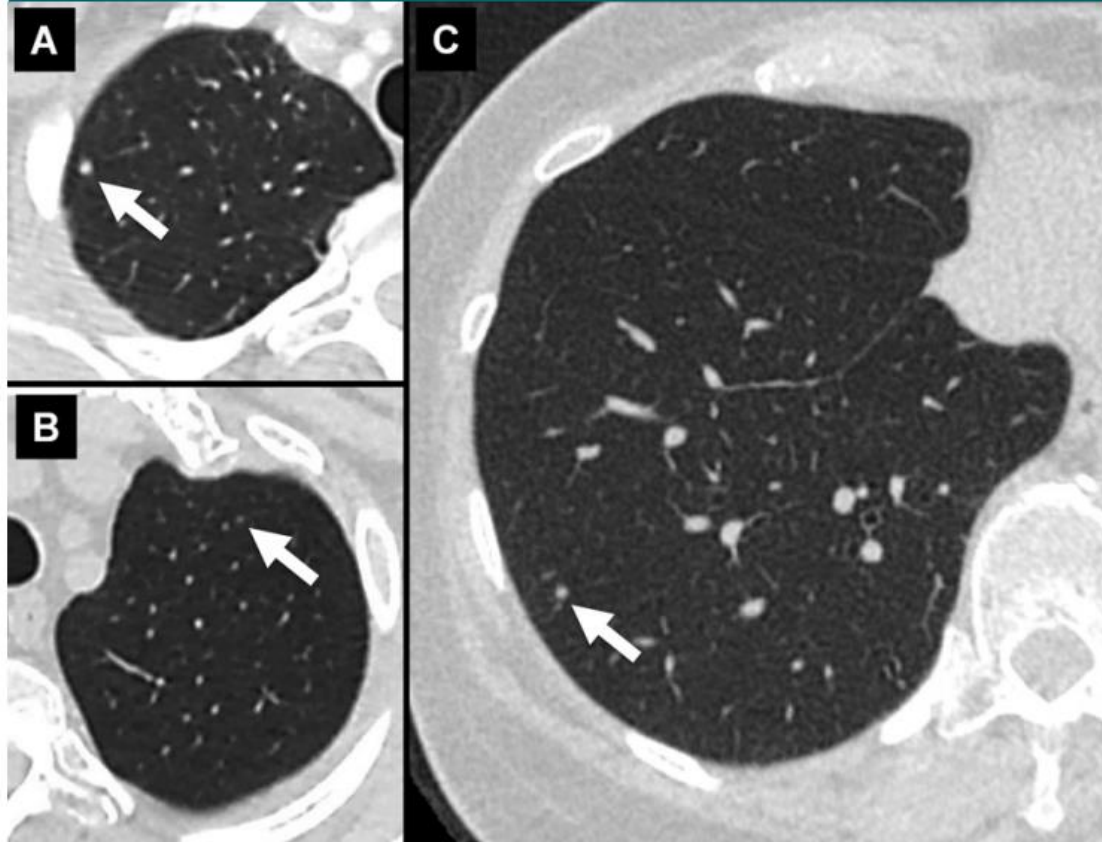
Transverse CT sections through nodules 3 mm or smaller (arrow) in the, *A*, right upper lobe, *B*, left upper lobe, and, *C*, right lower lobe. Such small nodules should not be measured, given inherent accuracy limitations and variability in determining whether the lesion is a solid, part-solid, or ground-glass nodule.
